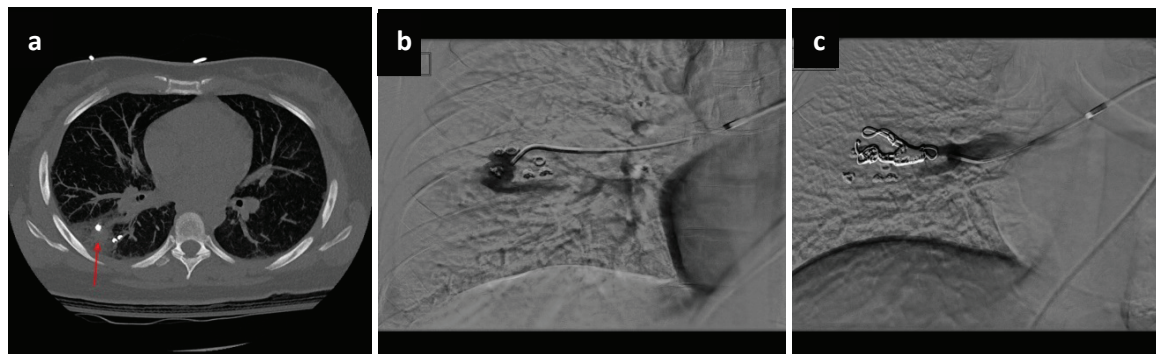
35 weeks' gestation. (a) Chest CT showed a soft tissue nodule (aneurysm) and parenchymal hemorrhage (red arrow). (b, c) Pulmonary angiography showed the embolization procedure with the catheter in the feeding artery demonstrating the aneurysm followed by the coils after embolization.
